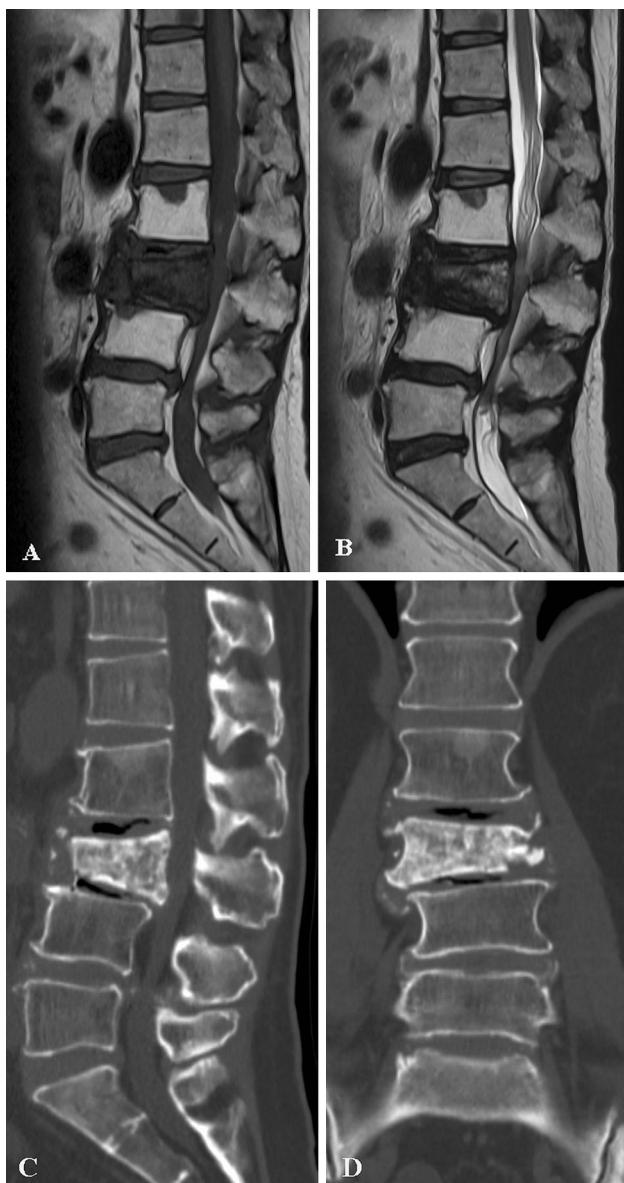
Sagittal a T₁-weighted and b T₂-weighted MRI images showing low signal intensity at L3. c, d CT showing a compression fracture and bone lysis at L3 at presentation in 2007
